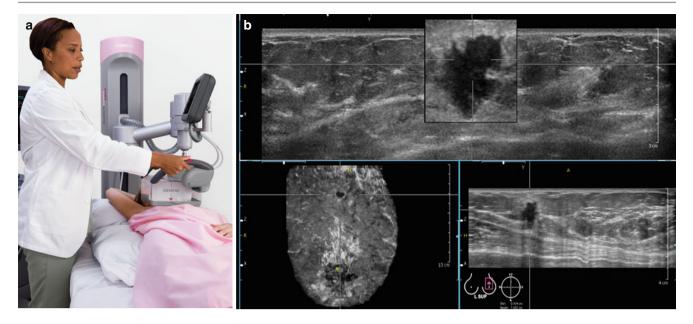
(a) Automated whole-breast ultrasound unit with large footprint transducer covering breast. (b) Breast cancer outlined in three orthogonal views (Images courtesy of Siemens Healthcare)
